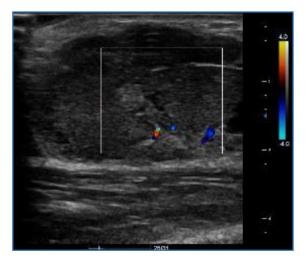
Ultrasound doppler examination of right breast showing a large heterogenous solid mass with vascularity
